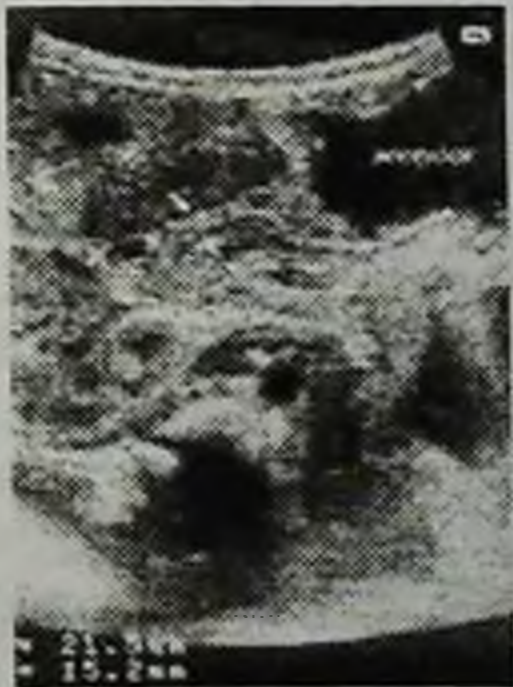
Ultrasound picture of pyloric stenosis
